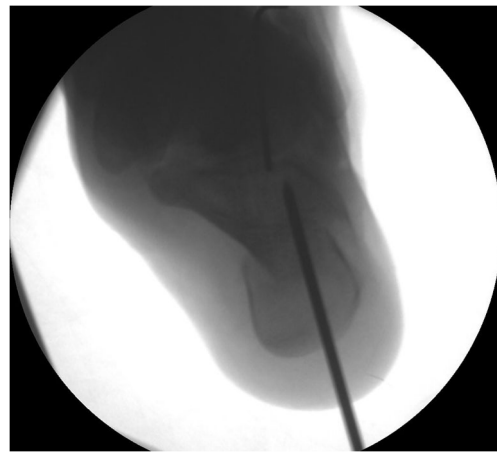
Patient A10 intra-operative axial image intensifier X-ray showing lateral calcaneal translation of 8.32 mm (3.2 mm guide wire is used as a marker for measuring)
